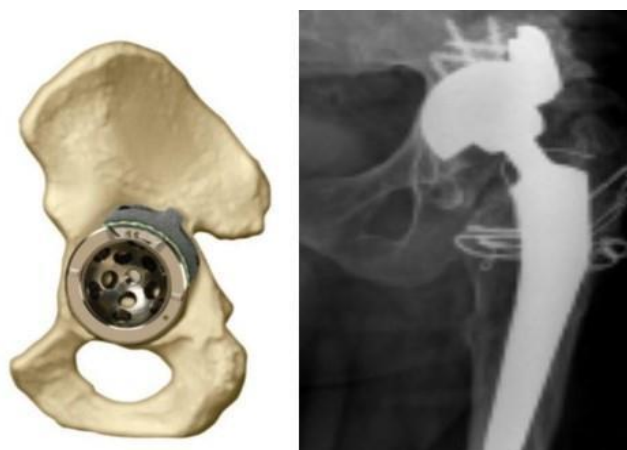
Flying buttress position. Algorithmic and postoperative X-ray ⁽⁷⁴⁾.
